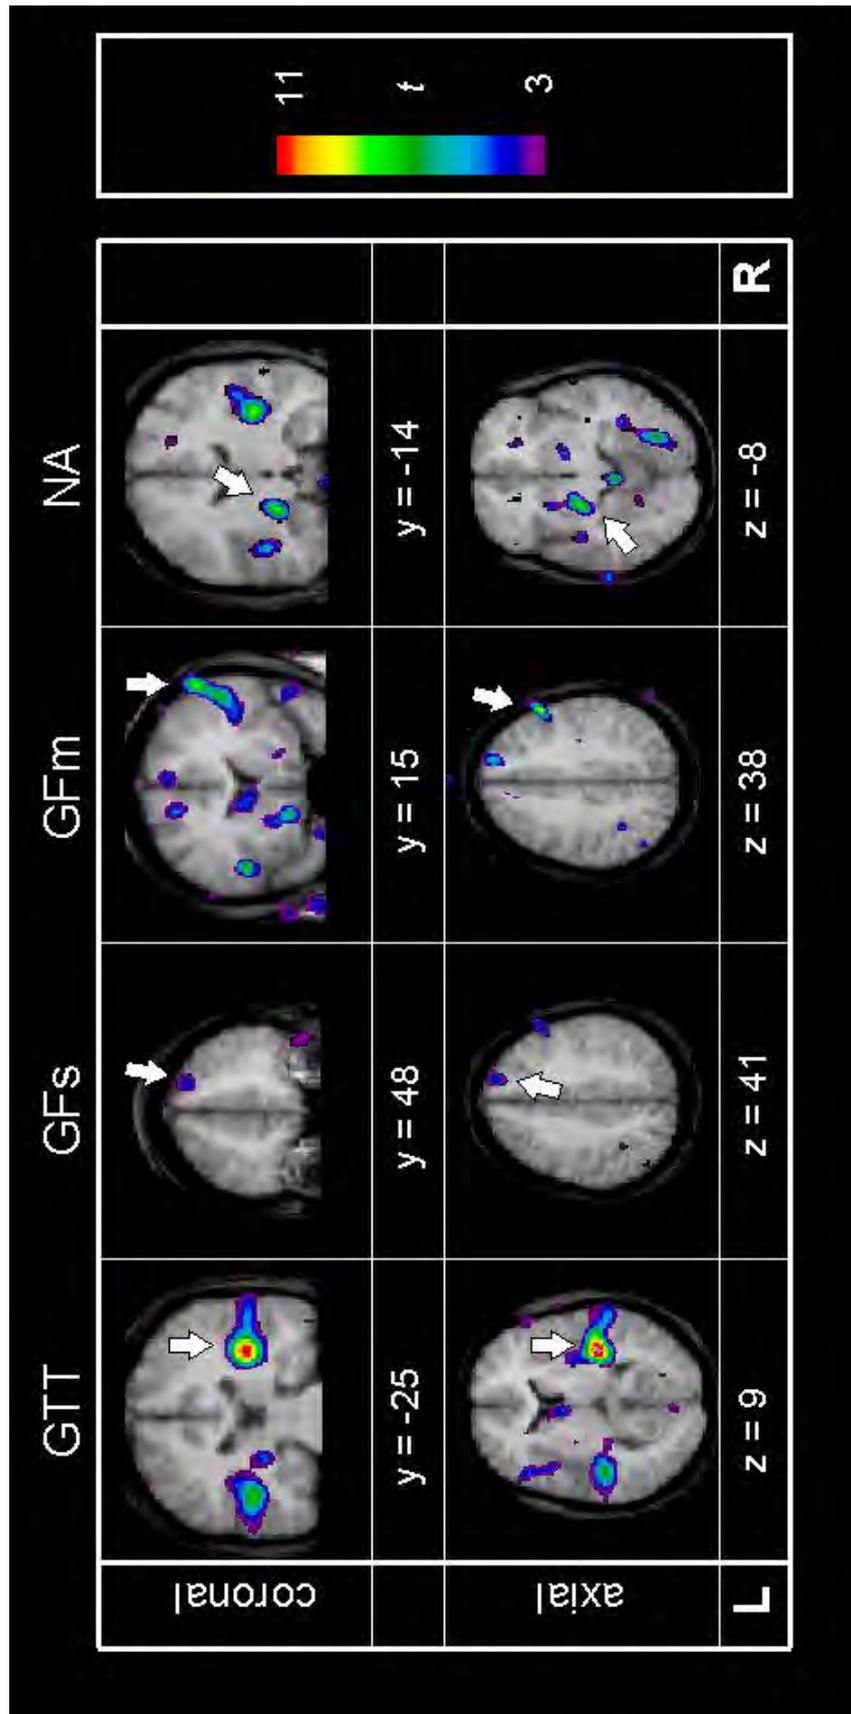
The t statistic map of the analysis of all test conditions (ASavg - B1) superimposed on coronal (upper row) and axial (lower row) slices of the average brain MR image of all 7 subjects. Selected peaks of activation corresponding to sites of activation given in Table 1 are indicated by white arrows. Dotted lines represent position of the intersectional plane between axial and coronal images. Coordinates (y and z) according to Talairach [11]. R: right, L: left. Other abbreviations: see Table 1.
